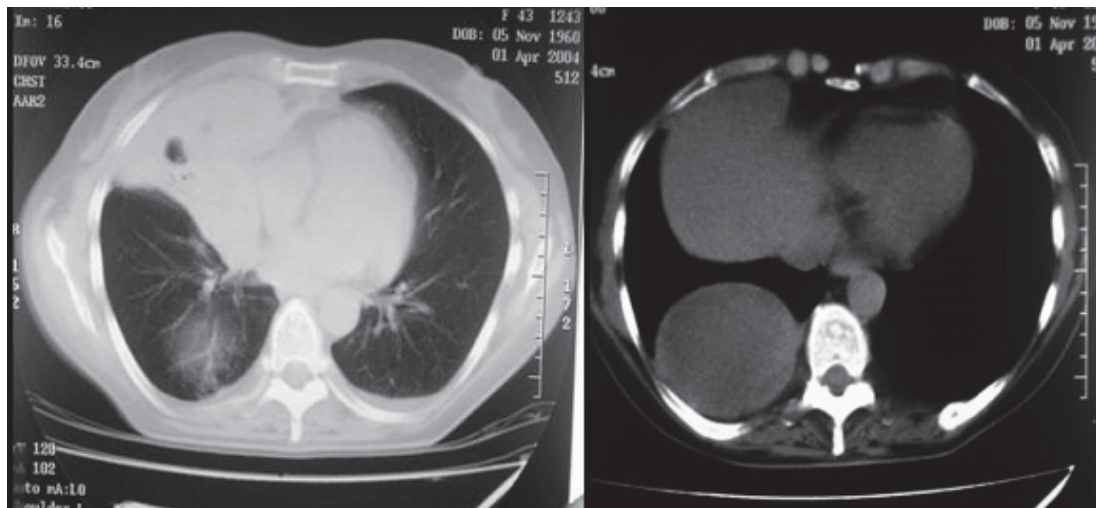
Computed tomography of the chest in the presented patient: large cavitary pneumonia and abscess in the right lung.
